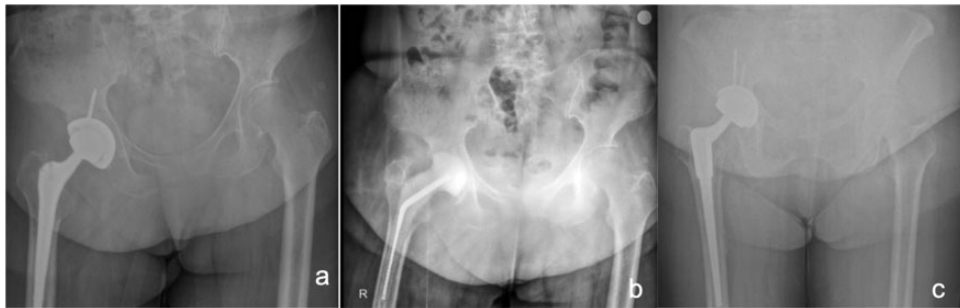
(a) Preoperative X-ray of Case 2 showing THA with no visible signs of loosening, despite clinical symptoms of pain and swelling in the right hip. (b) Postoperative X-ray of Case 2 showing the placement of a vancomycin- and gentamicin-loaded spacer (OGMHS®) following removal of the infected hip prosthesis and (c) final follow-up X-ray of Case 2 at 18 months showing a well-fixed revision THA prosthesis (Wagner SL Revision® Stem) with no evidence of loosening or infection recurrence. THA: total hip arthroplasty.
